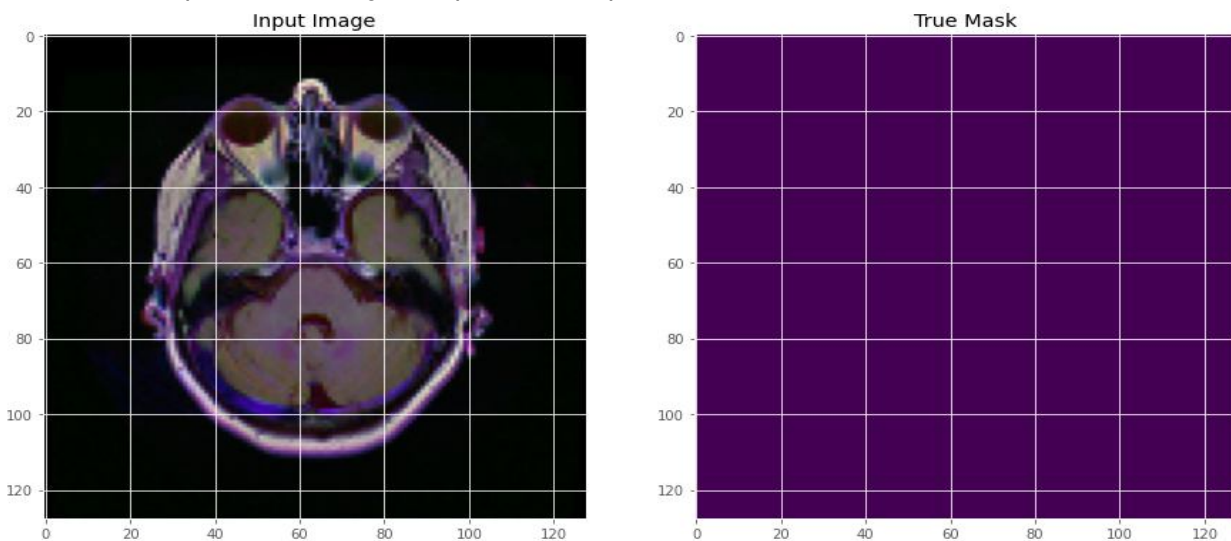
MRI image and True mask Result
